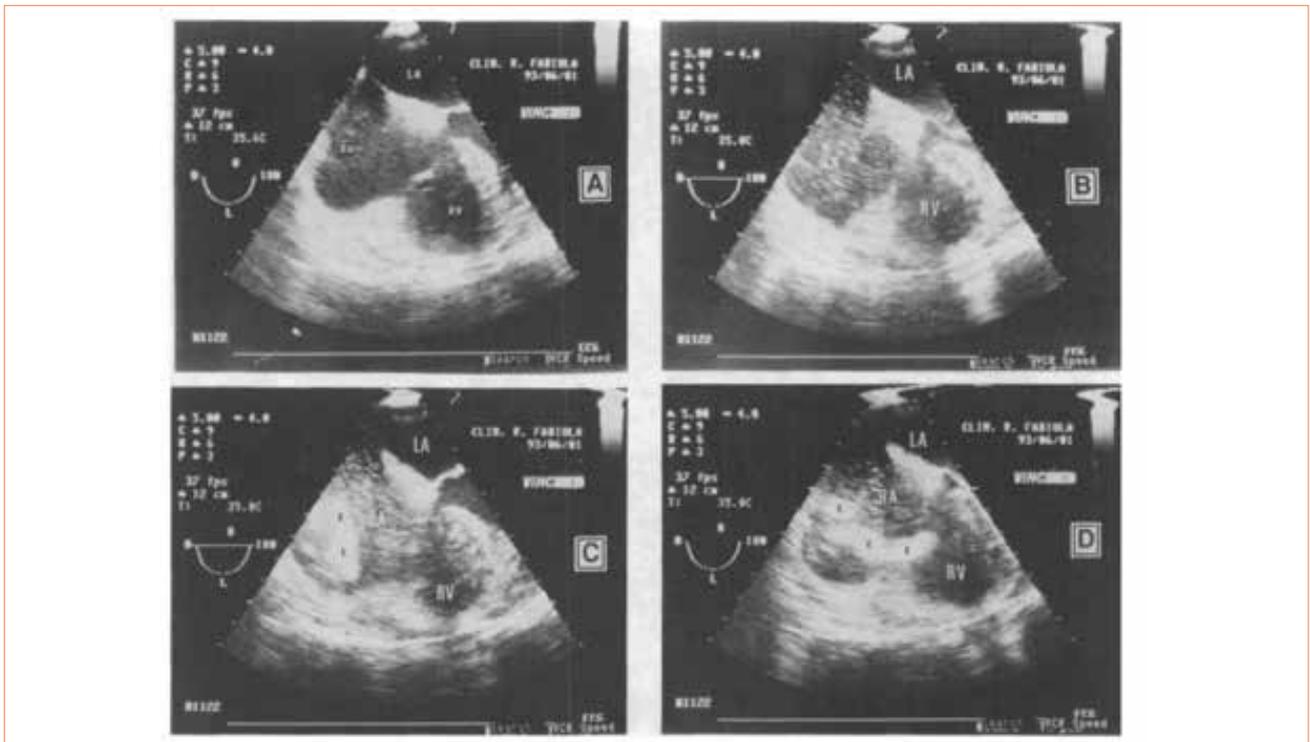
Four-chamber transesophageal echocardiographic views showing embolism during total hip arthroplasty: (A) control view, (B) “snow flurry” in the right atrium, (C) small and large emboli in the right atrium, (D) large emboli in the right atrium with delayed passage at tricuspid valve. Abbreviations: E, embolus; LA, left atrium; RA, right atrium; RV, right ventricle; SF, snow flurry. (Reproduced with permission from *Canadian Journal of Anaesthesia*.¹⁴)
